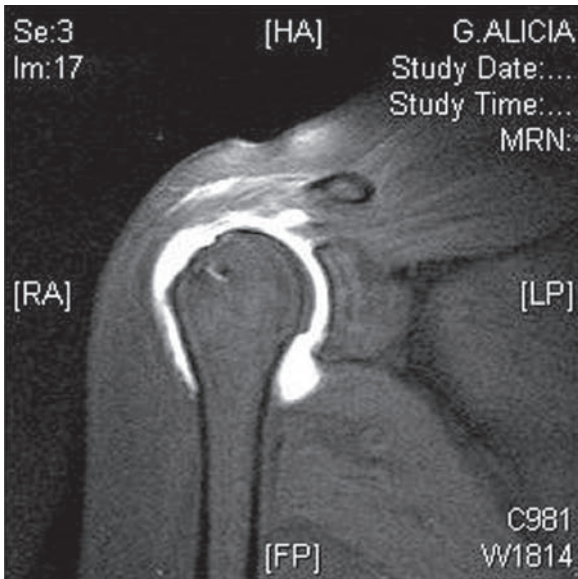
Coronal slice from arthro-MRI of shoulder showing contrast leakage suggestive of a frank rotator cuff re-tear.
